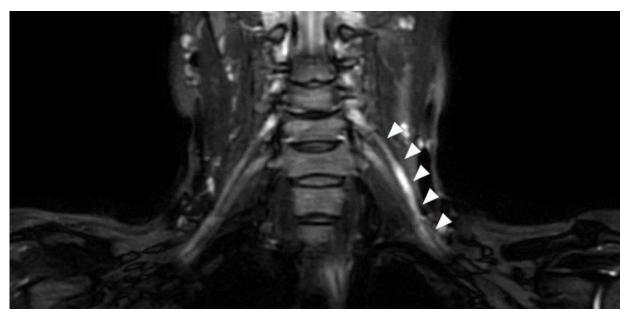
MRI of a 52-year-old woman with neuralgic amyotrophy. Coronal T2-weighted STIR image. Asymmetrical hyperintensity is observed from the distal of left C5 nerve root to upper trunk and the proximal portion of the C5 nerve root has no difference in T2 signal intensity compared to the right side (white arrowhead).
